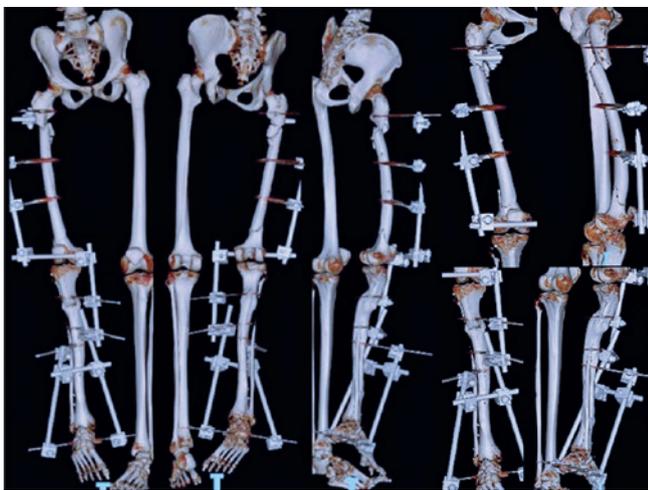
Computed tomography with 3D reconstruction showing subtrochanteric and distal femur fractures. Note the severity of the anterior bowing of the femur. The 3D reconstruction of the tibia also shows multiple tibial deformities and fracture at the level of the ankle arthrodesis.
